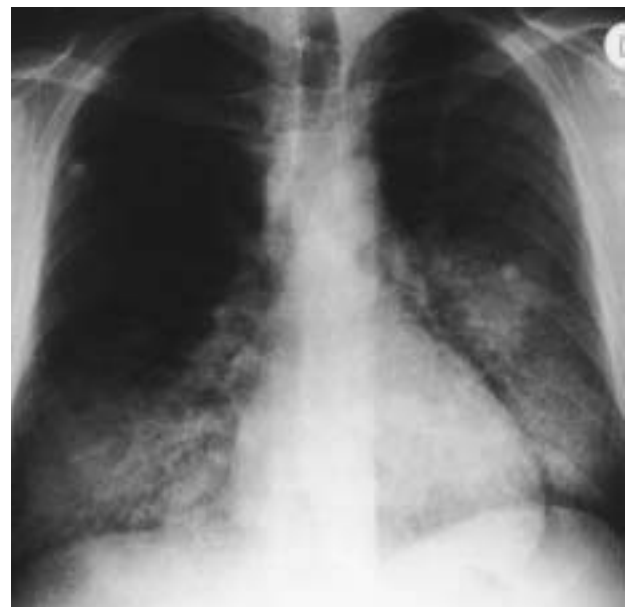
Chest radiograph on day 5 showing bilateral alveolar/interstitial infiltrates.
